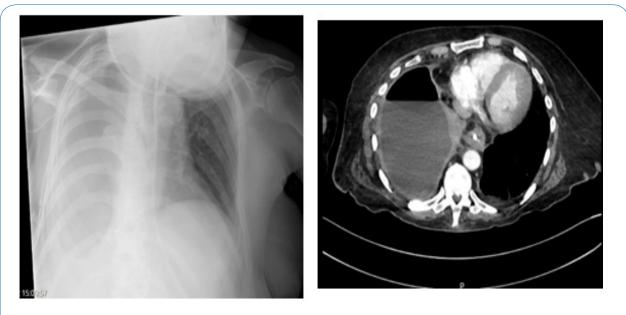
CXR and CT images showing right sided empyema with pleural enhancement.
